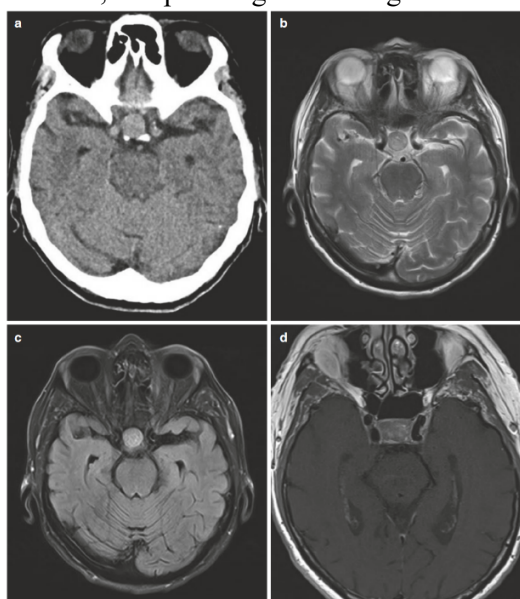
CT/MRI findings of a pituitary macroadenoma, including axial CT (a), coronal T2-weighted MRI (b), FLAIR (c), and contrast-enhanced axial T1-weighted MRI (d) (Source: Weis *et al.*, 2019)
